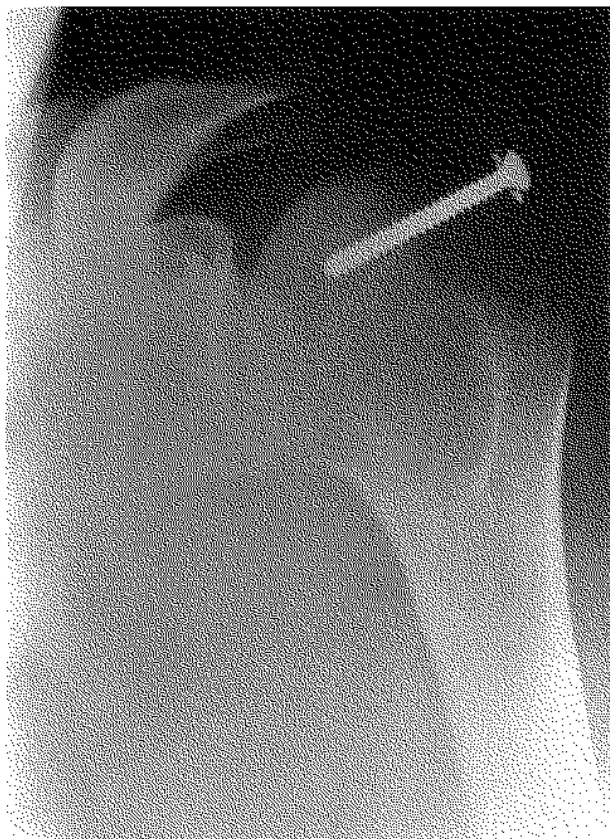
Postoperative radiograph showing screw and washer fixation of the cuff.
